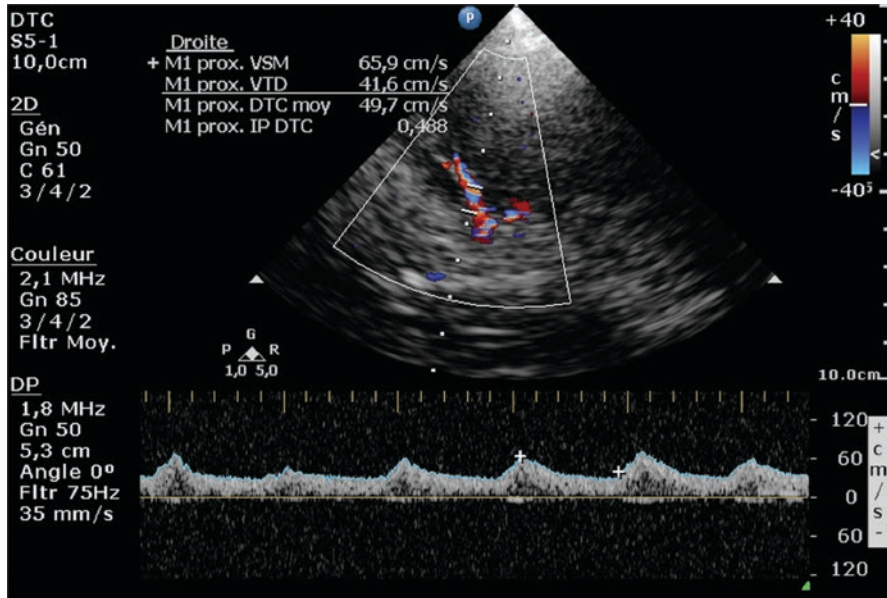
Typical transcranial Doppler (TCD) recording from the middle cerebral artery after traumatic internal carotid artery dissection (TICAD)
